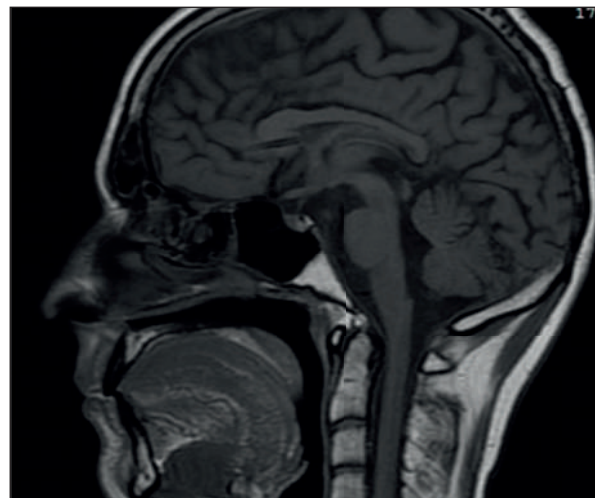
Postoperative contrast-enhanced brain MRI of a 31-year-old man: absence of pineal germinoma recurrence after surgery followed by radiation and chemotherapy. Sagittal plane.
